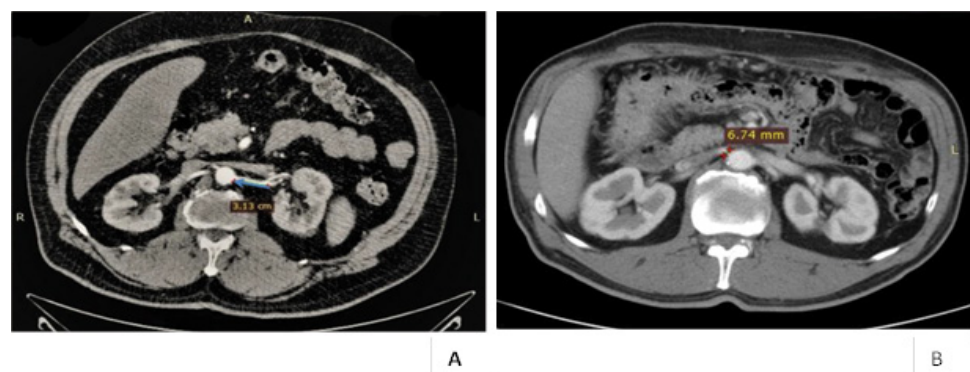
CTA of renal arteries A-B, measurement the length of LRR (A), measurement the diameter of RRA (B).
